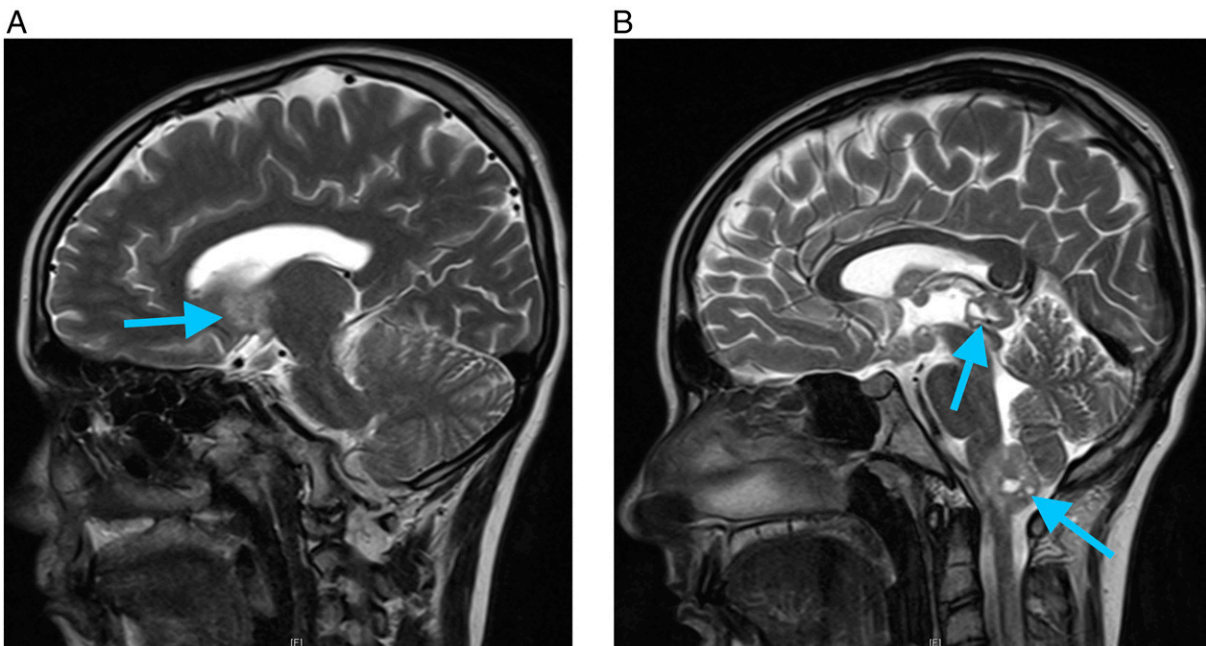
Sagittal T2-weighted magnetic resonance images show enhancing masses marked by arrows in the (A) suprasellar area, (B) pineal region, and the (B) cervical medullary junction. The patient also had a small left cerebellar mass and a tumor in the foramen of Monroe (not shown). The radiologic differential for multiple midline tumors in a patient this age included pinealoblastoma or germ cell tumor with ependymal spread.
